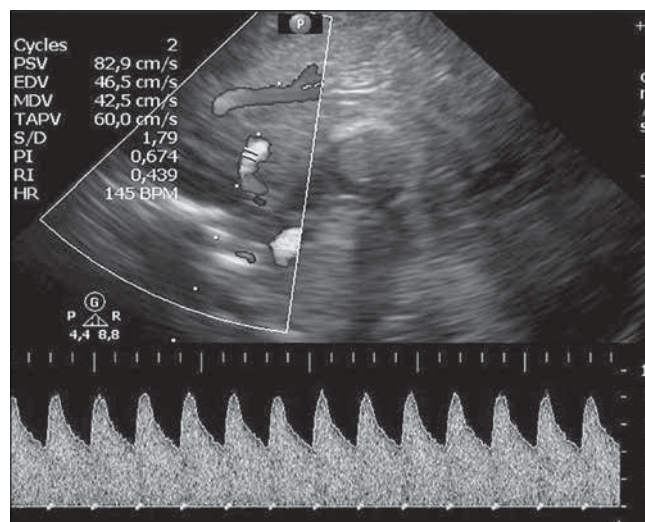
US. Color Doppler evaluation shows a high cerebral blood flow velocity with very low RI in ACA, RI=0.44 (sagittal view).
